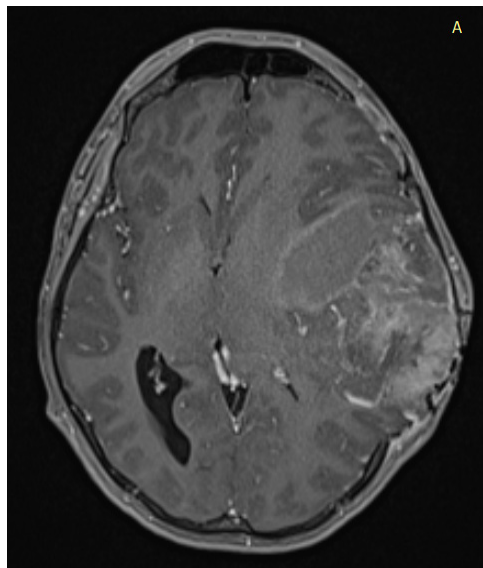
Magnetic resonance imaging (MRI) brain
